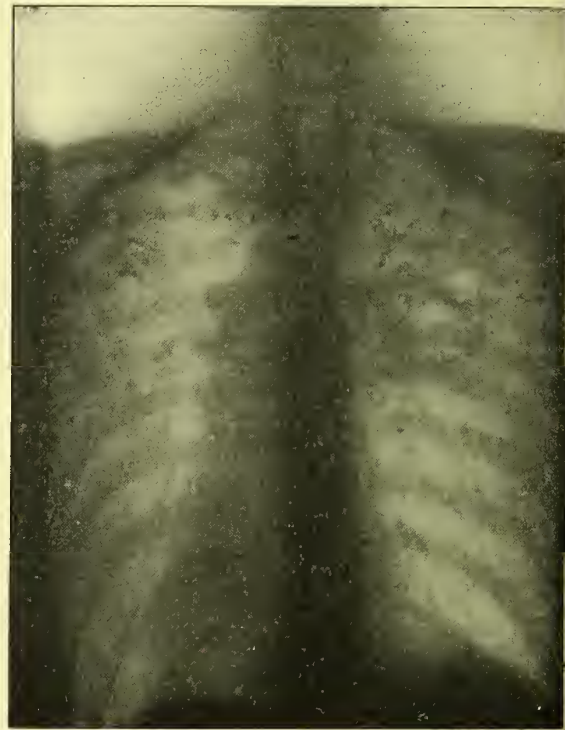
Skiagram of chest of young lady, æt. 32 years, showing spread of tuberculosis from hilus to apices, particularly on the right side, where the mottled areas may be seen filling up the space between the hilus shadow and the apex. Note also the elongated tubercle-like heart. Notwithstanding the history of a slight cough for two years, and the presence of tubercle bacilli in the sputum and the X-ray evidence of extensive disease of the right upper lobe, patient looked wonderfully well, and the physical signs were mainly confined to the right inter-scapular region, where there was slight dulness, prolonged expiration, and bronchophony. (Radiogram by Dr. Alfred Jordan.)
